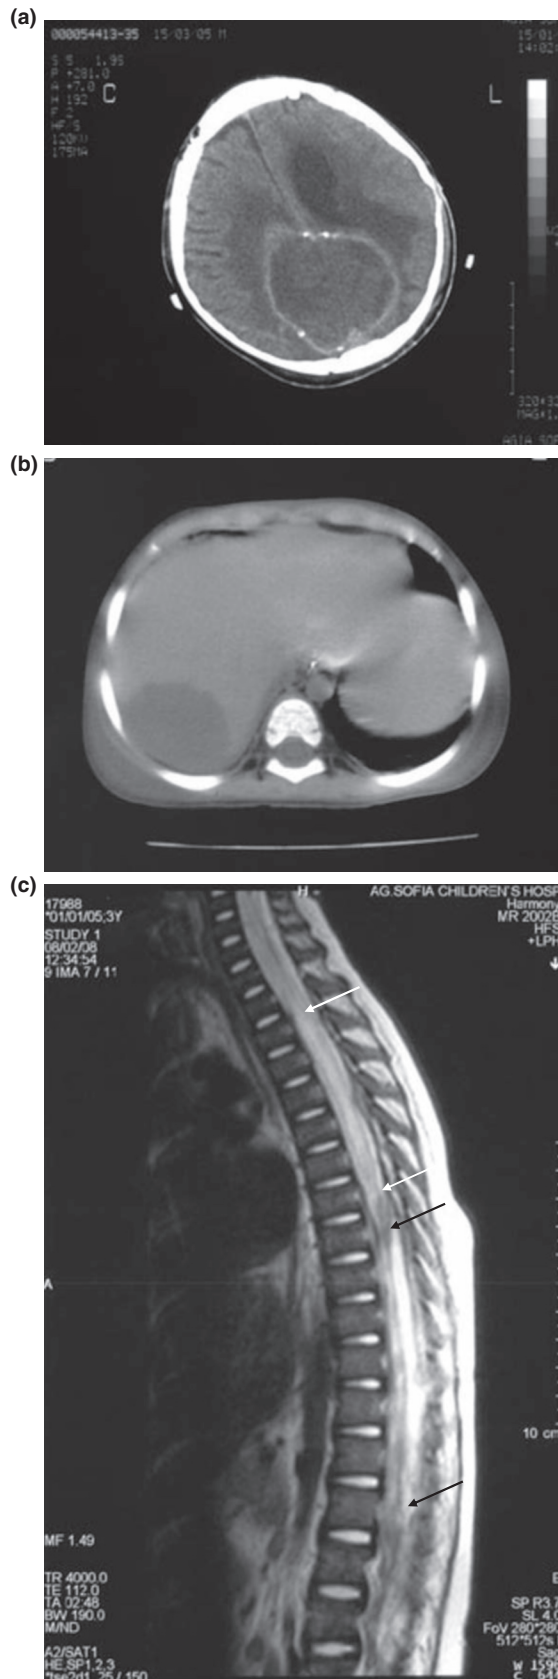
(a) Computed tomography (CT) scan showing a large, hypodense, interhemispheric mass lesion with ring contrast enhancement compressing both lateral ventricles with extensive surrounding oedema. (b) Abdominal CT scan showing two low density areas, one in the right liver lobe and the other in the border between the right and left lobes. (c) Spine magnetic resonance imaging T2-weighted image showing extensive intramedullary oedema of the thoracic spinal cord (white arrows) and epidural fluid entrapment at the thoracolumbar junction (black arrows).
